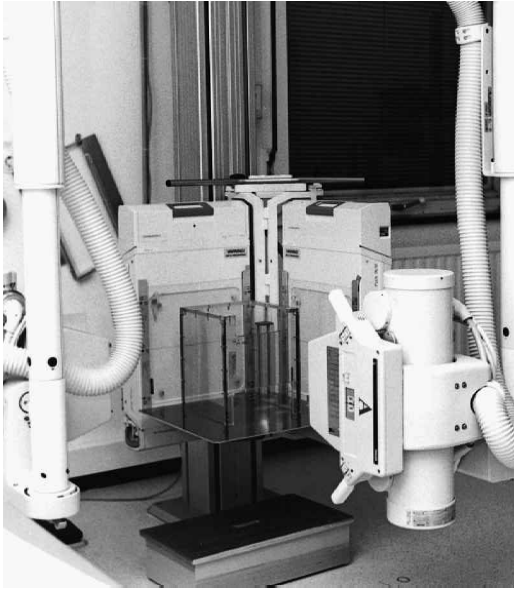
The radiographic set-up. Two film-exchangers angulated 90° in relation to each other are mounted on a stand, which enables adjustments in the proximal-distal directions to suit the length of the individual patient. Examination of the calibration cage and the reference plates is shown.
